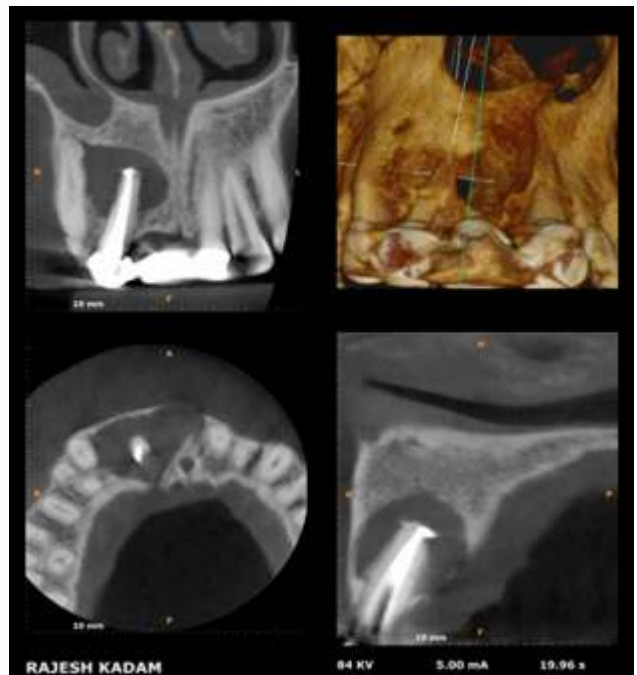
cone beam computed tomography for right maxilla
